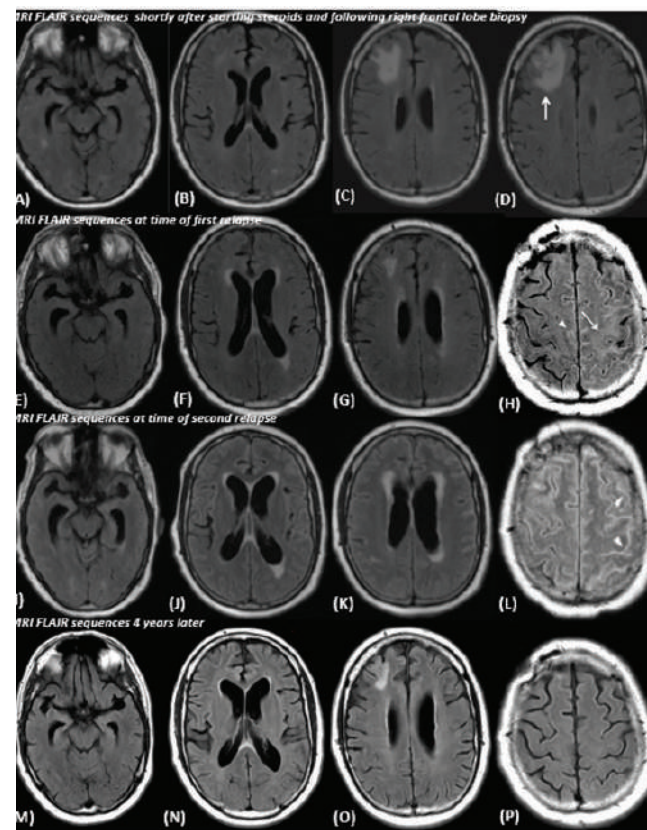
Serial MRI fluid-attenuated inversion recovery (FLAIR) images taken shortly after the right frontal lobe brain biopsy (A–D), at the time of the second relapse 3 months later (E–H), and at the time of the third relapse 1 month after that (I–L) demonstrated new and progressive ventriculomegaly with surrounding FLAIR signal changes. There is increased FLAIR high signal in the subcortical white matter (arrow, H) and in the subarachnoid space (arrowheads, H and L) despite treatment with intravenous cyclophosphamide. The right frontal lobe signal change was secondary to the biopsy (arrow, D). Long-term resolution of periventricular, subcortical, and sulcal FLAIR signal abnormality was noted 4 years after the start of rituximab treatment (M–P).
